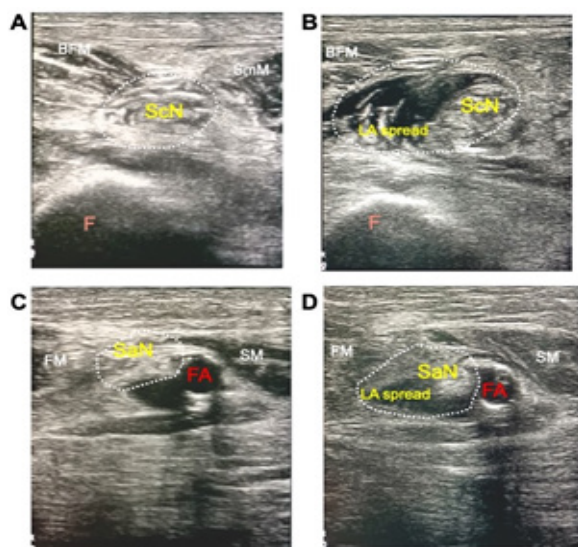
(A) Ultrasound image of Sciatic Nerve (ScN) before and (B) after LA injection; (C) Ultrasound image of Saphenous Nerve (SaN) before and (D) after LA injection in Adductor Canal Block. BFM, Biceps Femoris muscle; SmM, Semimembranosus muscle; SM, Sartorius muscle; VM, Vastus Medialis muscle.
